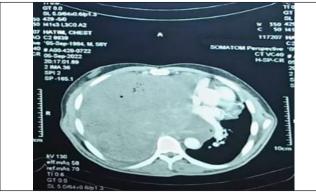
Pre-op CT-scan chest.
